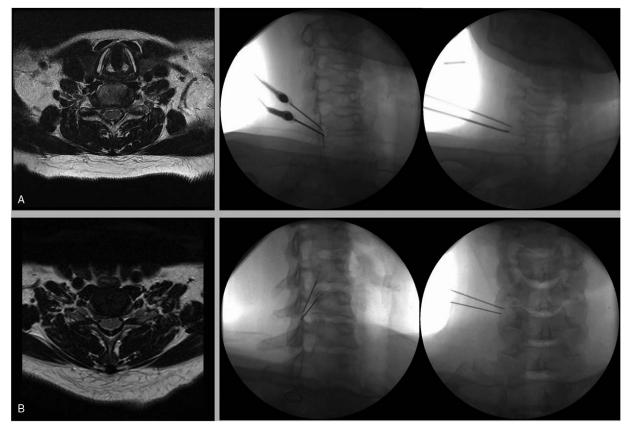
(A) Patient 1: axial T2-weighted cervical spine MRI at 8 months after symptom onset showed foraminal stenosis at the right C6–7 (right). Bipolar pulsed radiofrequency on the right C7 dorsal root ganglion was performed under the C-arm fluoroscopy (oblique and anteroposterior views) (left). (B) Patient 2: axial T2-weighted cervical spine MRI at 6 months after symptom onset presented with right central to right foraminal disc protrusion on C6–7 (right). Fluoroscopy-guided bipolar pulsed radiofrequency on the right C7 dorsal root ganglion was performed (oblique and anteroposterior views) (left).
